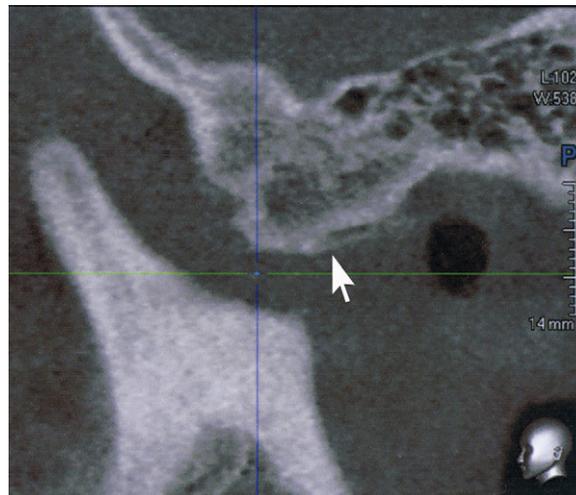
Cone beam CT showing that the skull base of the glenoid fossa was thickened, the fossa shape had disappeared and a prominent bone mass (arrow) was located in the glenoid fossa next to the residual ramus.
